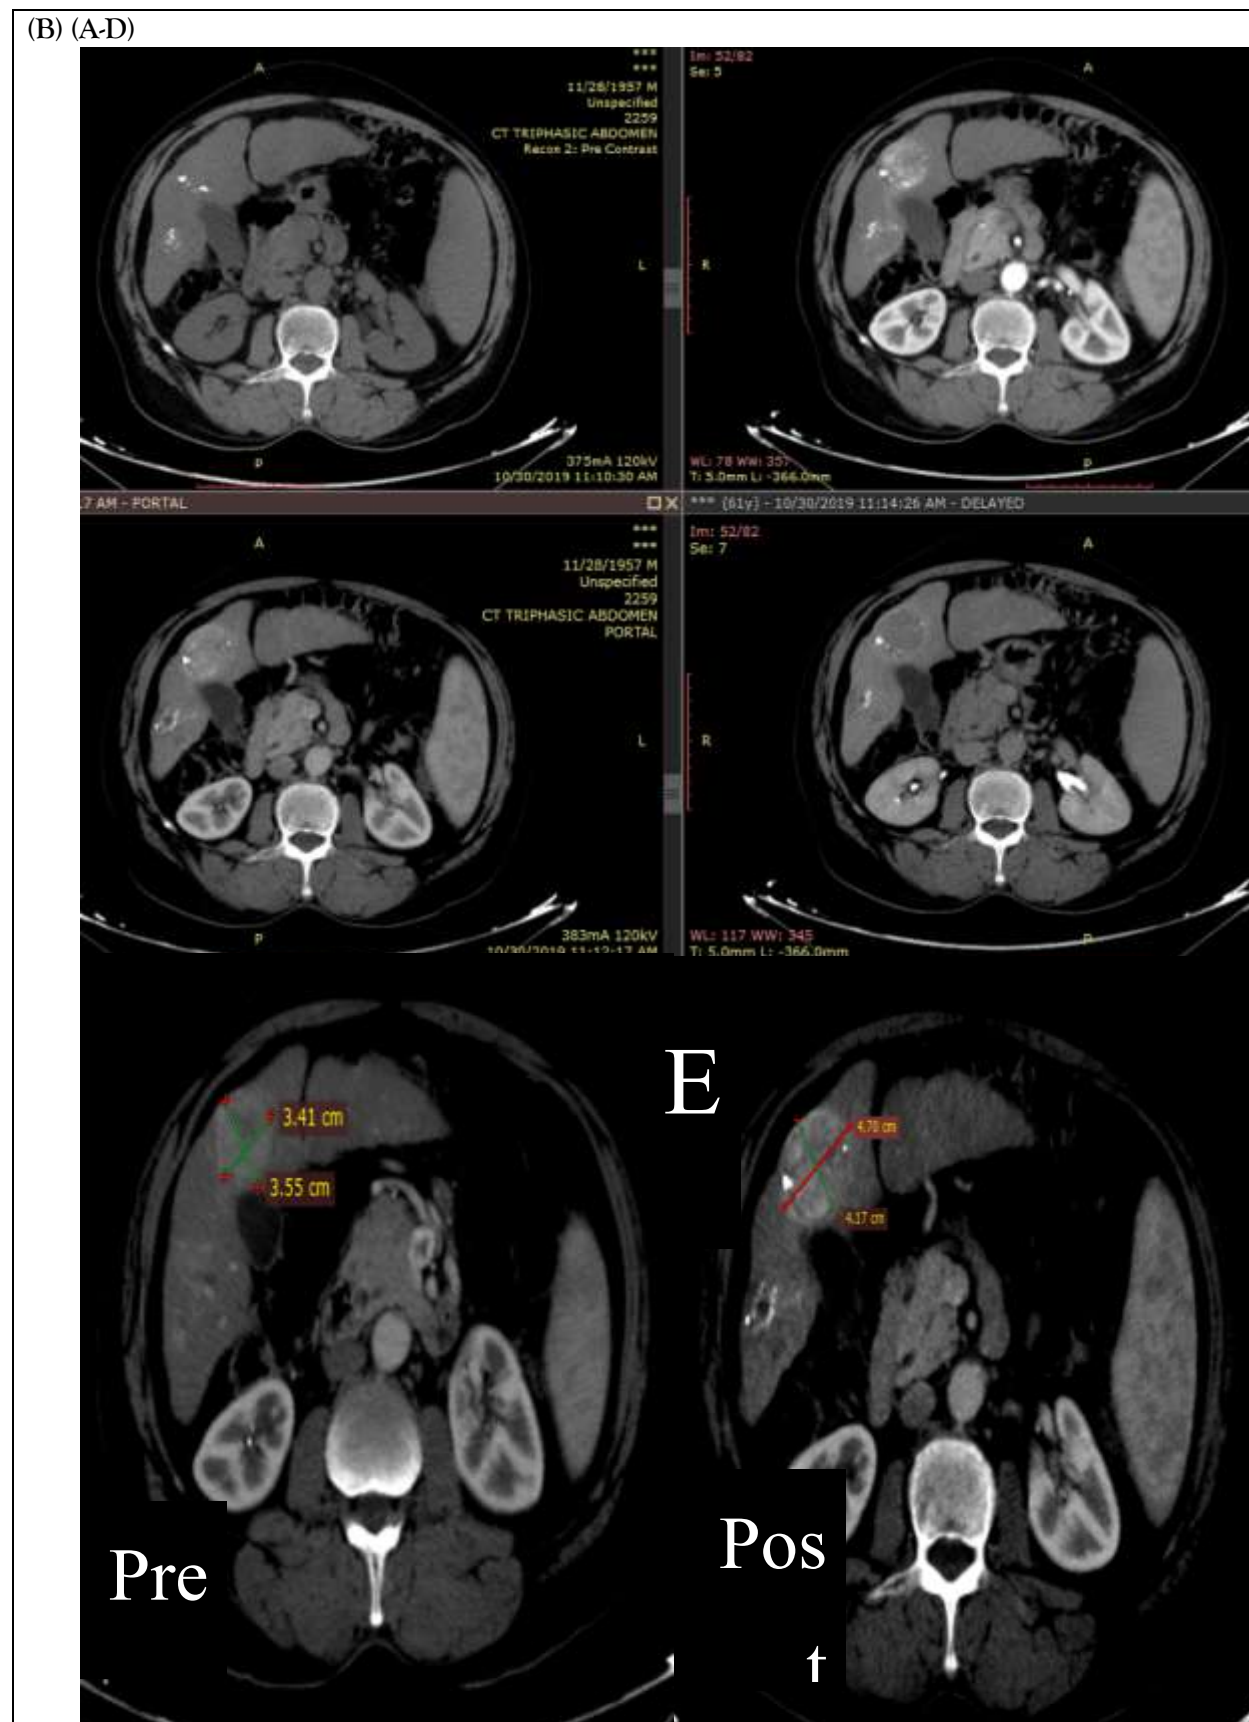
A: (A-D) This is the initial triphasic CT study showing the target lesion displaying an HCC enhancement pattern as well as other surrounding focal lesions.
